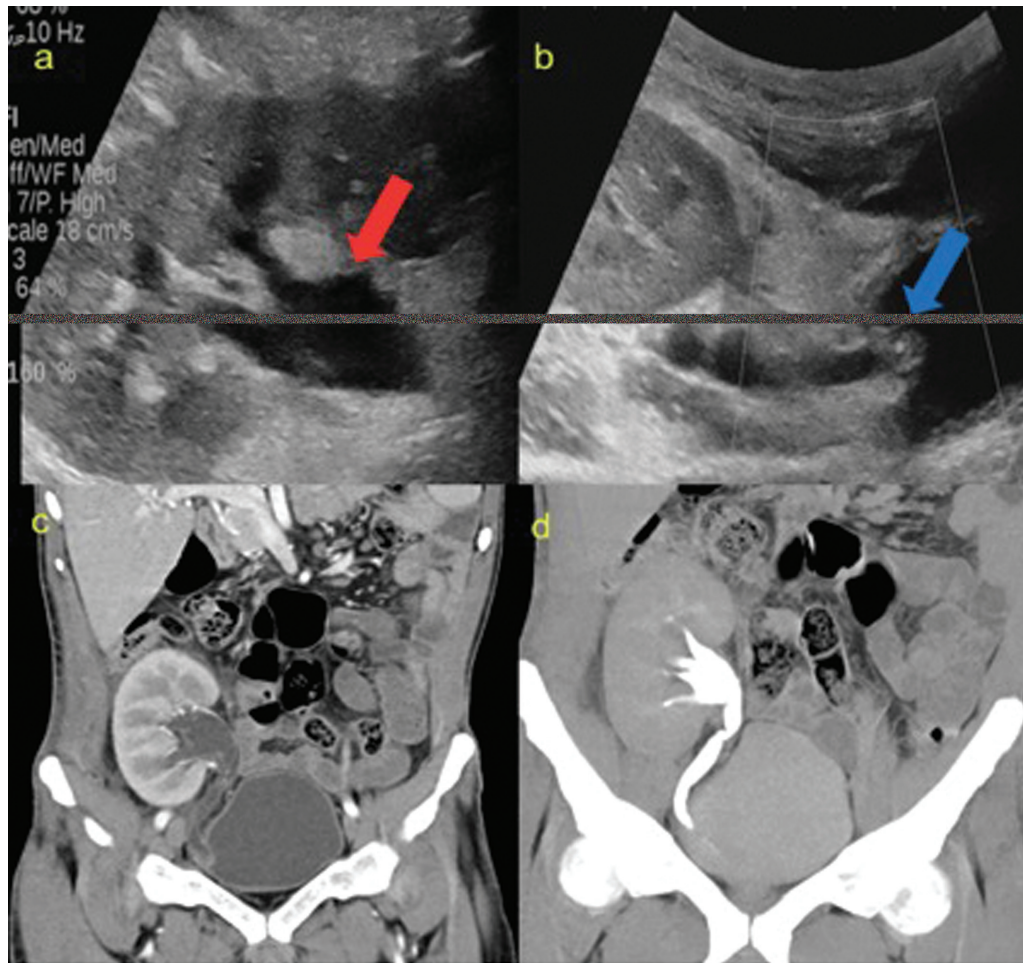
Ultrasound images (a and b) show dilatation of the pelvicalyceal system (red arrow) and ureter till the vesico ureteric junction (blue arrow). Contrast-enhanced CT images in the coronal plane in arterial (a) and (b) delayed phases show a transplanted kidney in RIF with nonobstructive hydroureteronephrosis. CT, computed tomography; RIF, renal interstitial fibrosis.
